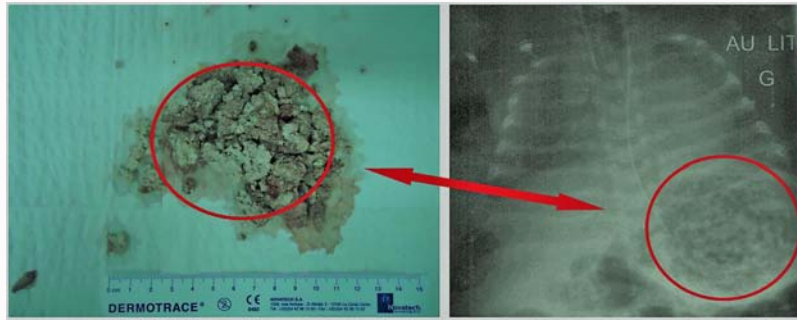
Macroscopic view of lactobezoar and his X-ray picture.
